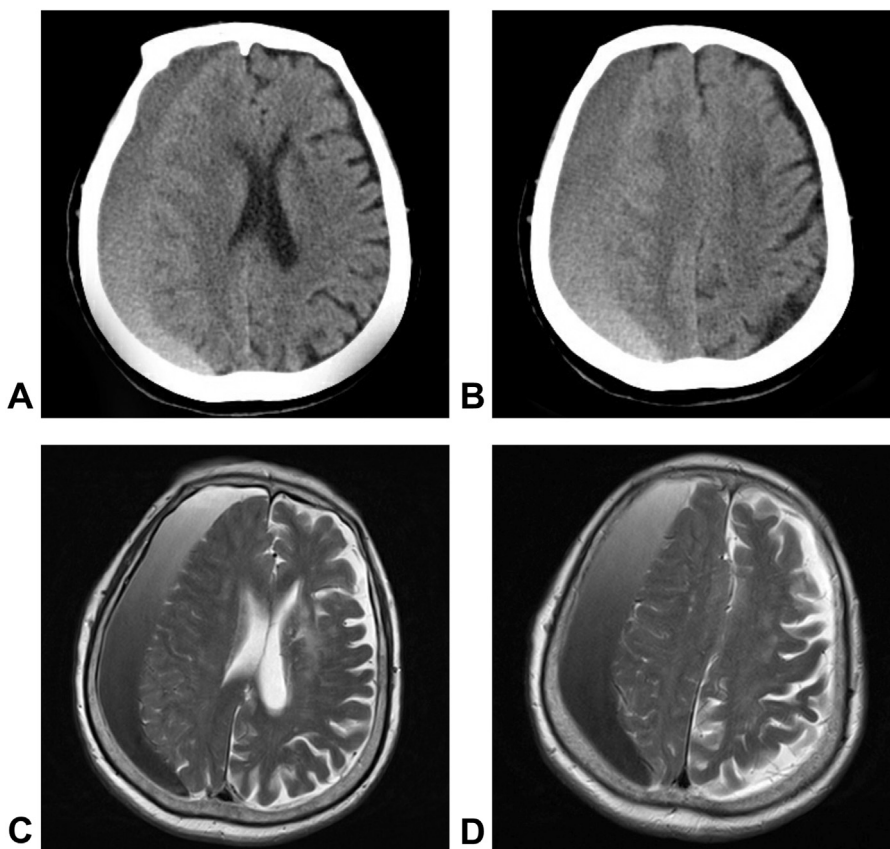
Preoperative images, CT scans and MRI showed a CSDH in the right hemisphere with a shift of the midline structures and lateral ventricle compression. A–B: brain CT images; C–D: brain T2-weighted MRI.
